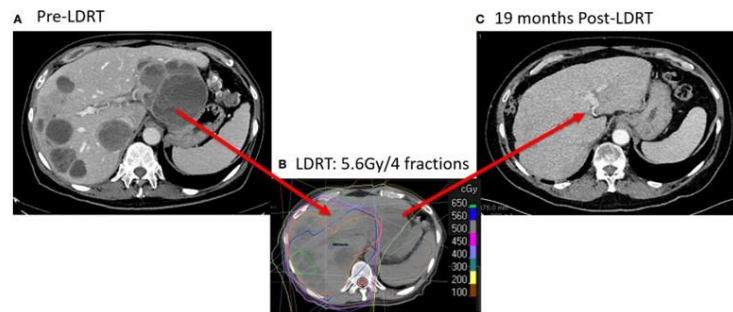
Low-dose radiation therapy (RT) to nearly the whole liver. (A) Computed tomography with contrast before RT. (B) Low-dose RT treatment plan (coronal).
